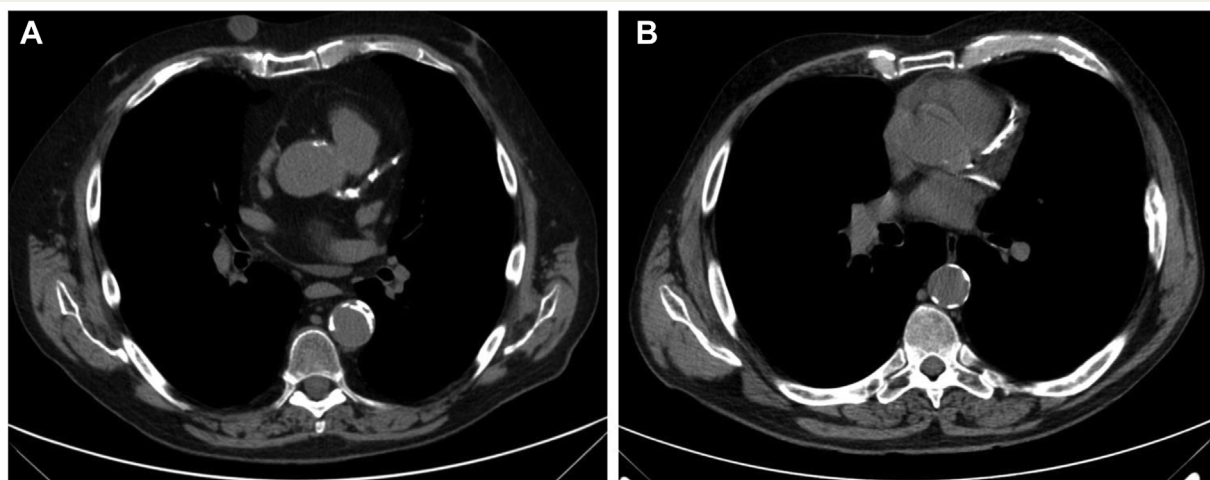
Case examples. A. Axial CT image demonstrating non-reported severe calcification in the left anterior descending artery. B. Axial CT image showing non-reported extensive calcification involving the left anterior descending and circumflex arteries.
